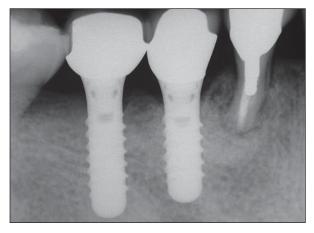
Radiograph obtained after 1 year of follow-up.
